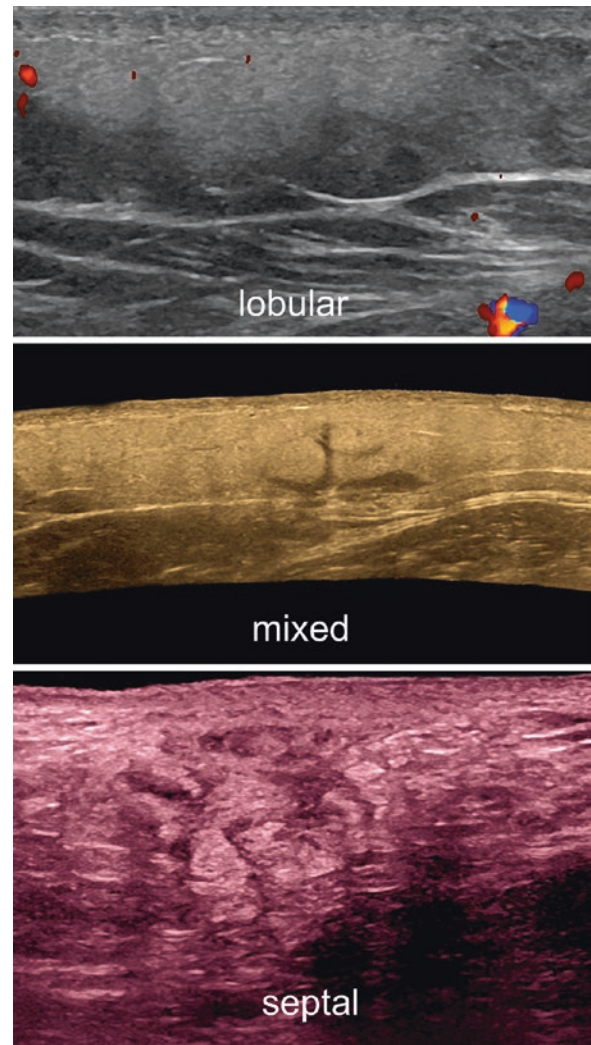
Key sonographic signs of lobular, mixed, and septal panniculitis.
